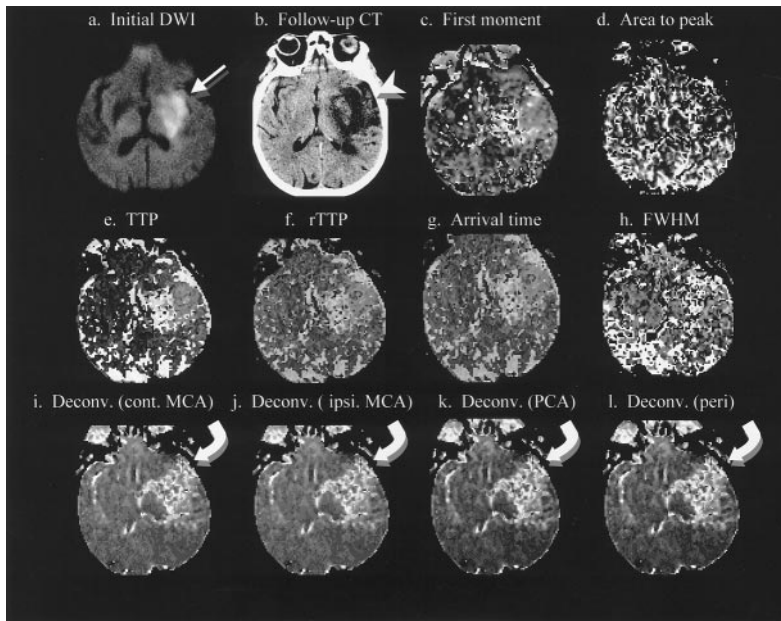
This 80-year-old woman presented with acute onset of aphasia and confusion. Initial DWI (a) showed an area of abnormality involving the left basal ganglia (arrow), which was later shown to be an infarct also involving the anterior temporal cortex (arrowhead) on follow-up CT (b). PWI at the time of onset using the first moment (c), time to peak (e), and relative time to peak (f) images demonstrated an area of abnormal perfusion in the left basal ganglia, but the cortical involvement was missed with these techniques. The deconvolution method (Deconv.; i through l) was the only calculation technique that showed an unequivocal area of cortical involvement in the anterior temporal MCA territory (curved arrows). Cont. indicates contralateral; ipsi, ipsilateral; and peri, peri-infarction arteries.
